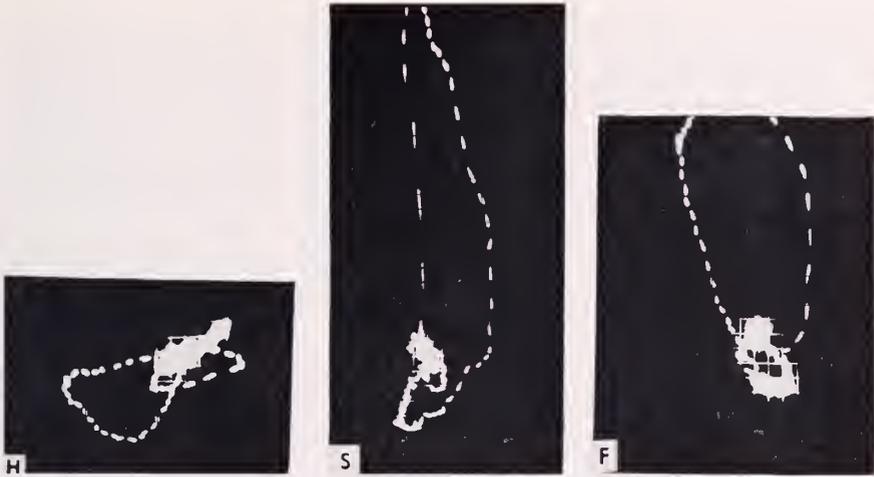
A. S., 65 year-old female with metastatic carcinomatosis of the liver. Radiographic examination of the chest reveals a rounded left cardiac contour and an increased cardiac transverse diameter. Marked arteriosclerosis of the aorta. No known hypertension, past or present. Moderately loud apical systolic murmur. No cardiac symptoms. The QRS loop is oriented superiorly, to the right and anteriorly. Its terminal half is more slowly inscribed than its initial segment. The T loop is discordant.
